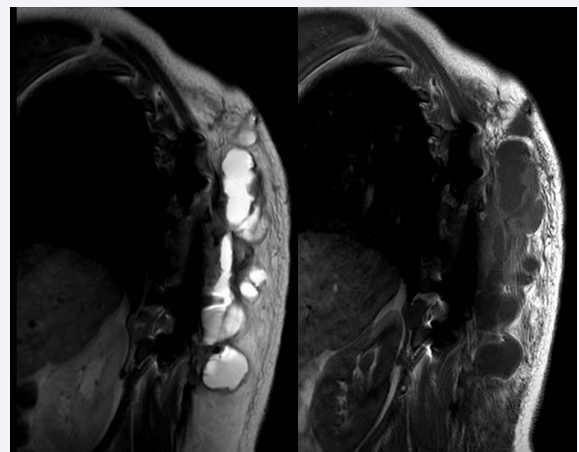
T2-w and T1-w MRI
